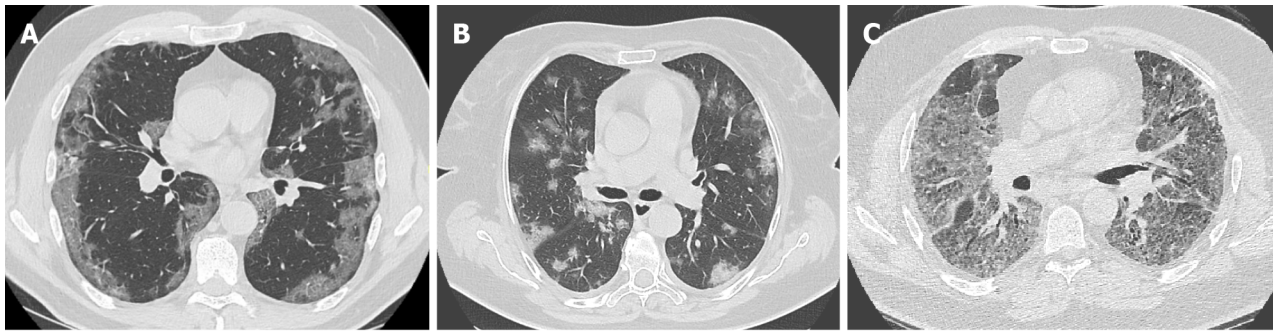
Axial computed tomography scans (7 days after symptom onset) show peripheral bilateral ground-glass opacities. A: Superimposed reticular interstitial thickening (red arrow) within the ground-glass opacities (GGO) giving a 'crazy-paving' appearance (black arrow); B: Air bronchogram (thick arrow) within the GGO.
